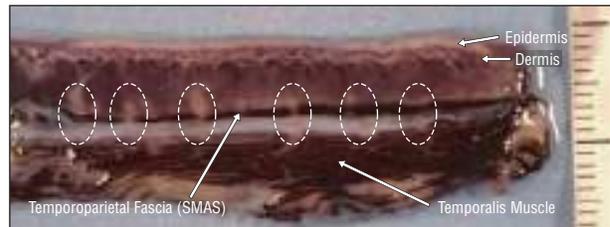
High-density line pattern of intense ultrasound exposures: left temporal area. The line of exposures is confined to the superficial musculoaponeurotic system (SMAS) layer (4.4 MHz/4.5 mm, 3.0 J). Dotted circles indicate thermal injury zones. Scale indicates 1 mm per division.
